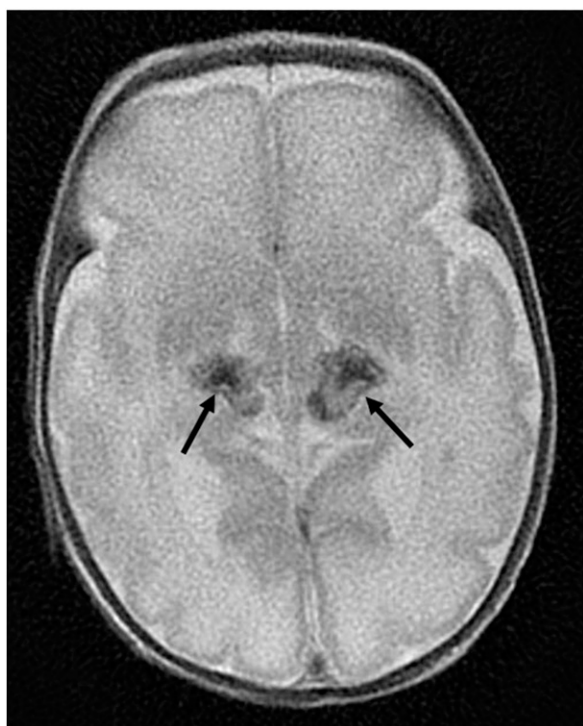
Brain magnetic resonance imaging scan (T2) 29 days after birth showing bilateral thalamic hemorrhage (arrows).
